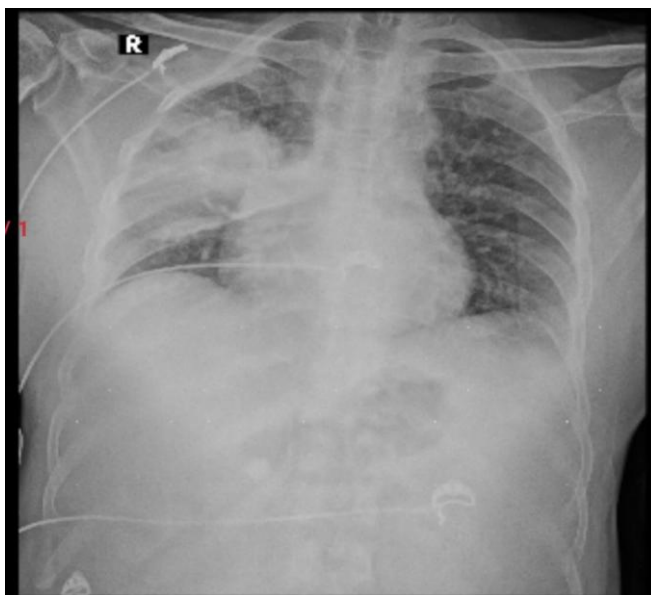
Chest X-ray on day of admission.
